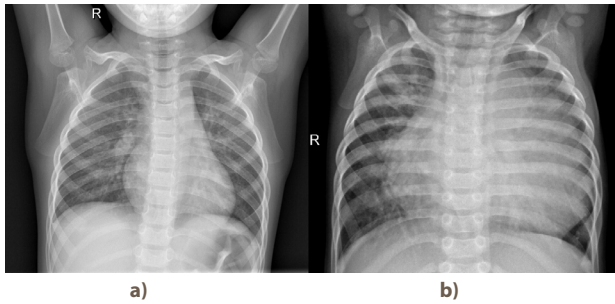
X-ray samples from Kaggle Chest X-ray Pneumonia dataset: a) normal lungs; b) pneumonia affected lungs (source: Mooney, 2018)
